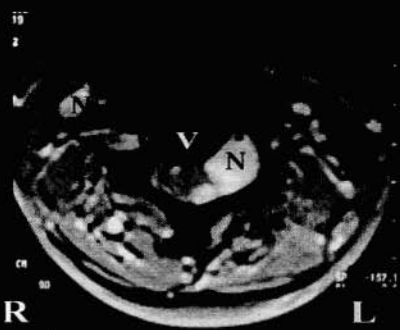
Axial MRI (T1-weighted sequence with contrast) of C4 cervical cord (S): bilateral paraspinous neurofibromas (N) with contrast enhancement. V = vertebral body.
